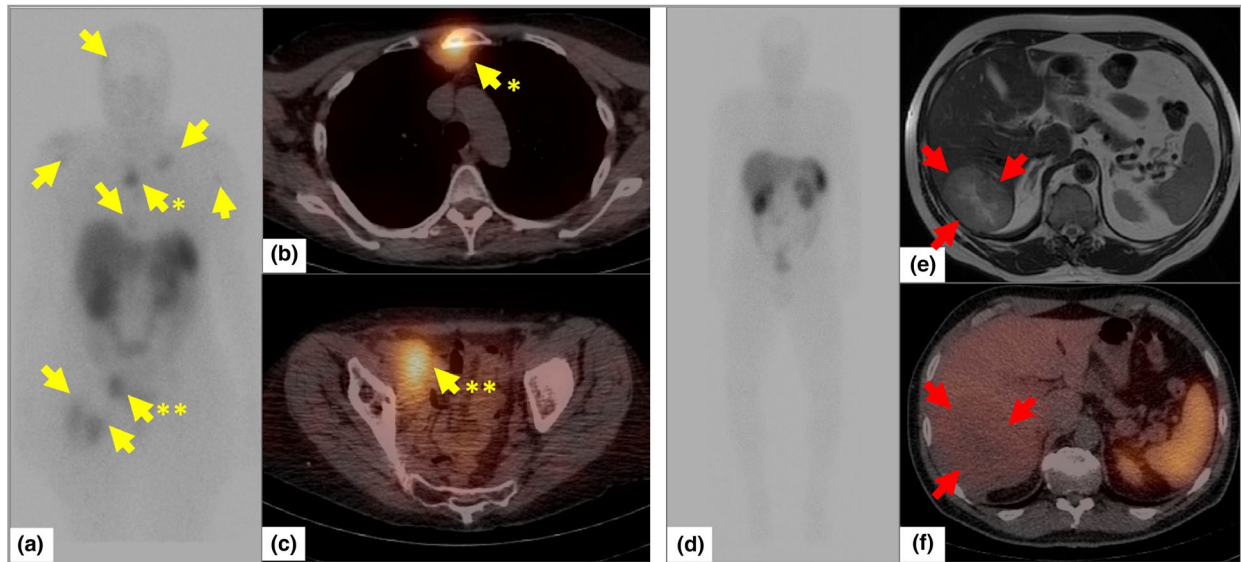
Examples of two patients with Merkel cell carcinoma (MCC) tumours that were positive and negative, respectively, for ^{111}In -pentetreotide uptake on somatostatin receptor scintigraphy (SRS). (a–c) A patient with MCC tumours that bound ^{111}In -pentetreotide. (a) The whole-body planar SRS image demonstrates several foci of increased radiotracer uptake, shown by yellow arrows. (b, c) Fused single-photon emission computed tomography with computed tomography localized a prominent lesion in the sternum, shown by a yellow arrow with an asterisk (b), and in the right external iliac node marked with two asterisks (c). (d–f) A second patient, with an MCC tumour negative for ^{111}In -pentetreotide uptake. (d) Despite the patient having a known, large MCC tumour in the liver, only physiological uptake was noted on whole-body planar imaging. (e, f) However, with SRS, a liver mass seen on magnetic resonance imaging (red arrows) (e) showed ^{111}In -pentetreotide uptake equal to or less than that in the blood pool, suggesting lack of somatostatin receptor expression (f).
